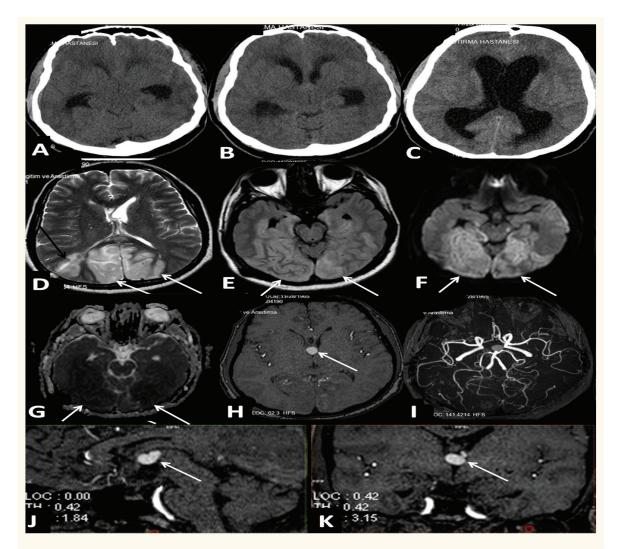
A–K: Preoperative computed tomography (CT) and postoperative magnetic resonance (MR) images of the patient. A, B & C: Preoperative sequential axial CT images showing hydrocephalus and periventricular oedema. D, E, F & G: Postoperative axial T2-weighted, fluid-attenuated inversion recovery (FLAIR), diffusion-weighted and apparent diffusion coefficient (ADC) images showing the shunt catheter (black arrow), bilateral occipital infarction (white arrows) and the decreased diameters of the lateral ventricles. H: Axial time-of-flight MR angiography (TOF-MRA) source image showing the hyperintense colloid cyst at the foramen of Monro (arrow). I: The calibrations of the posterior circulation arteries were normal on the axial maximum intensity projection (MIP) TOF-MRA image. J & K: Sagittal (J) and coronal (K) reformatted images obtained from the TOF-MRA sequence showing the hyperintense colloid cyst at the foramen of Monro level (arrows).
